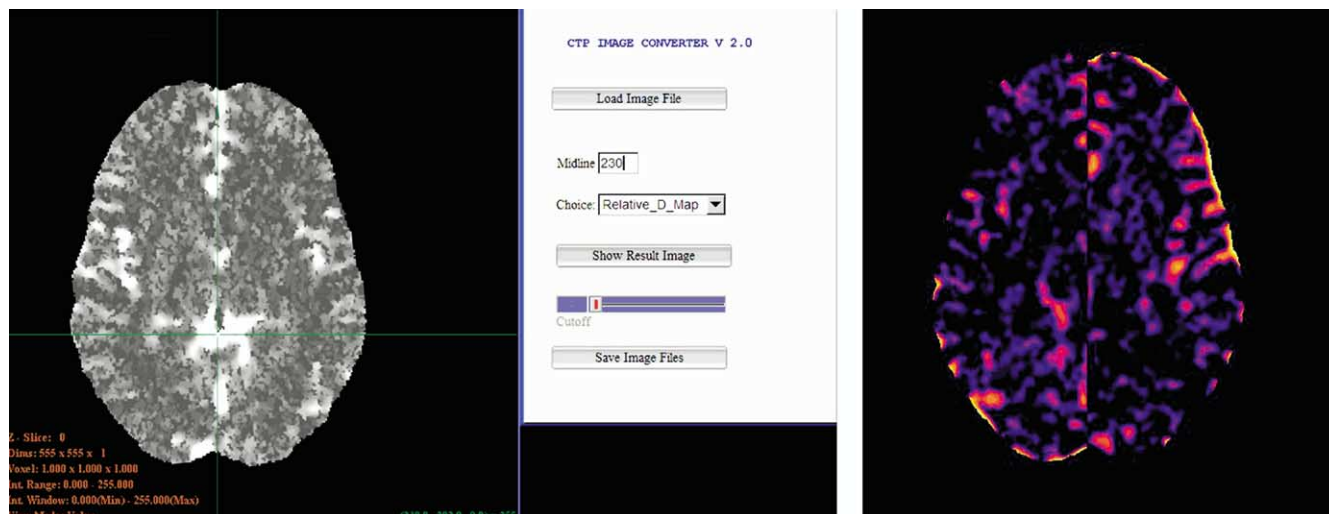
Relative difference map for CBF: (a) CBF image displayed by Siemens' perfusion software; (b) CT input CBF with selected midline, (c) output RDM.
